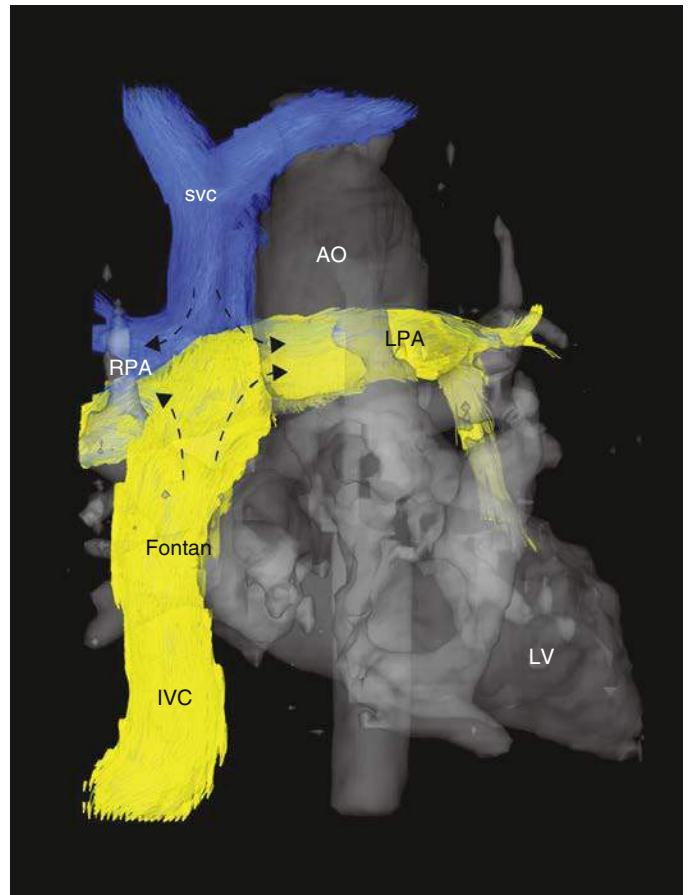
Four-dimensional flow magnetic resonance imaging (MRI) of inferior vena caval flow from the extracardiac Fontan as it meets the superior vena cava flow. The importance of off-setting of the two flow channels can be appreciated. IVC, Inferior vena cava; LPA, left pulmonary artery; LV, left ventricle; RPA, right pulmonary artery. (Courtesy Kelly Jarvis, PhD Candidate; Joshua Robinson, MD; and Michael Markl, PhD; Northwestern University.)
